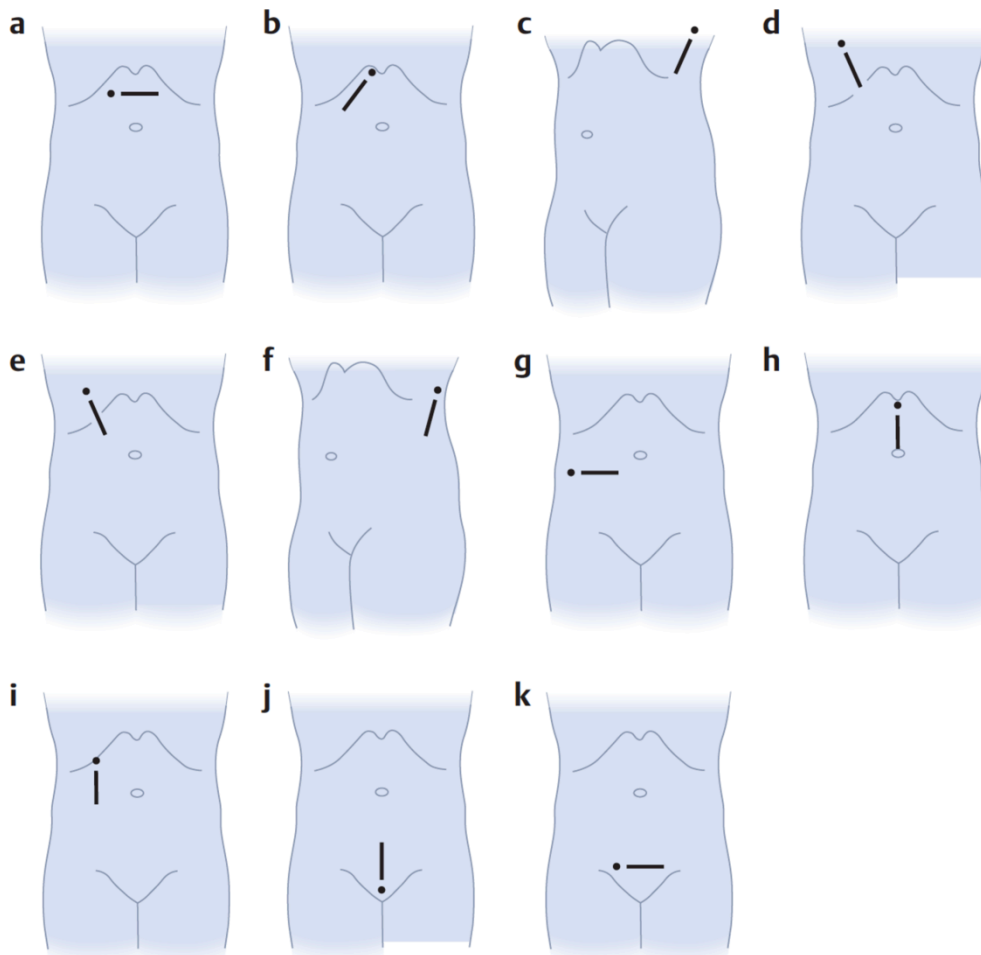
Standard planes for abdominal ultrasonographic scans. The thick black line indicates the position and plane of the curved transducer while the black spot at its one end indicates the position of the thumb. a: Upper abdominal transverse plane. b: Oblique subcostal plane (in the image on the right side; a symmetric plane is used on the left side). c: Upper lateral intercostal plane (right or left). d: Intercostal plane (right or left). e: Extended intercostal plane (right or left). f: Pubic plane (right or left). g: Mid abdominal transverse plane (right and left).
